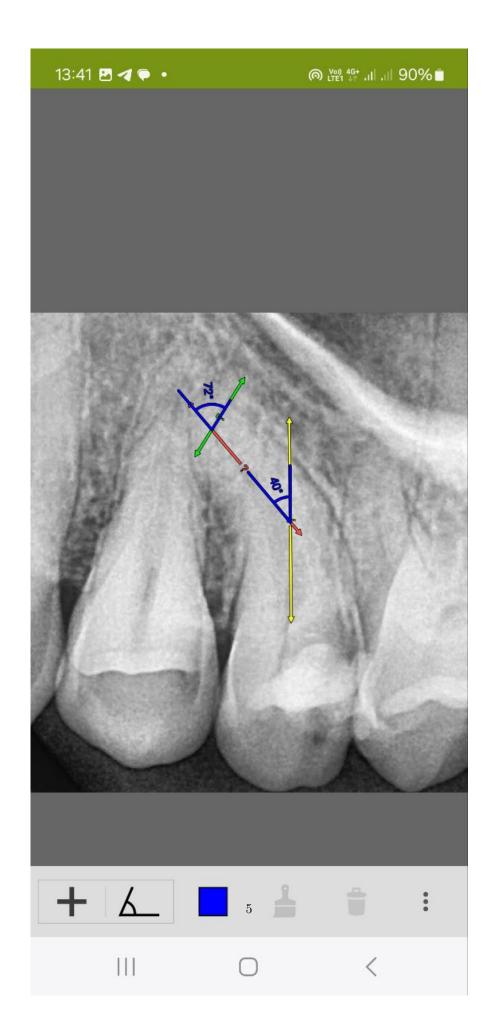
A) Initial periapical radiograph of the premolar, B) Master cone fit in the prepared canal, C) post-op periapical radiography, D) Follow-up after 15 months showing treatment outcomes, E)Curvature angle calculation by Southard approach.
